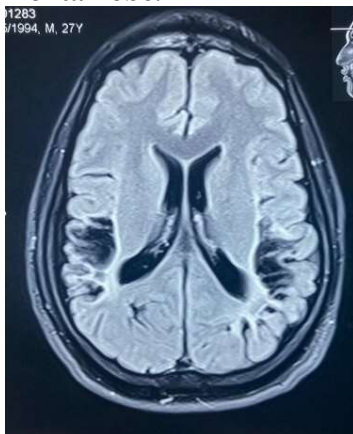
Axial FLAIR image of MRI showing bilateral parietal post hypoxic encephalomalacia.
